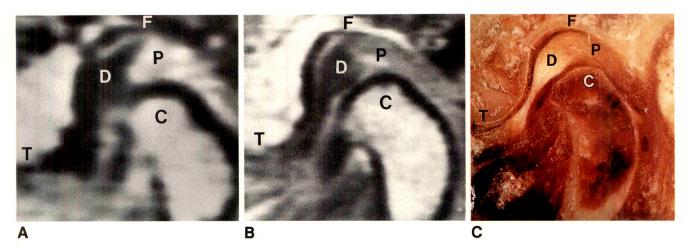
A and B, MR images obtained at 0.3 (A) and 1.5 T (B) show normal disk position. Anterior is to left. Quality of 1.5-T image was rated superior to that of 0.3-T image.
